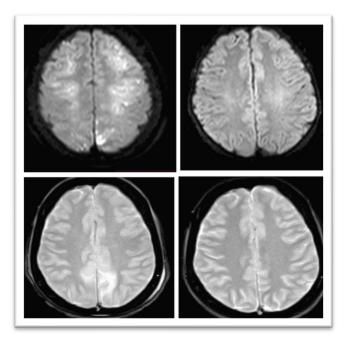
Magnetic Resonance Imaging showing high signal intensity in the cortical and subcortical white matter of the bilateral frontoparieto-occipital regions.
